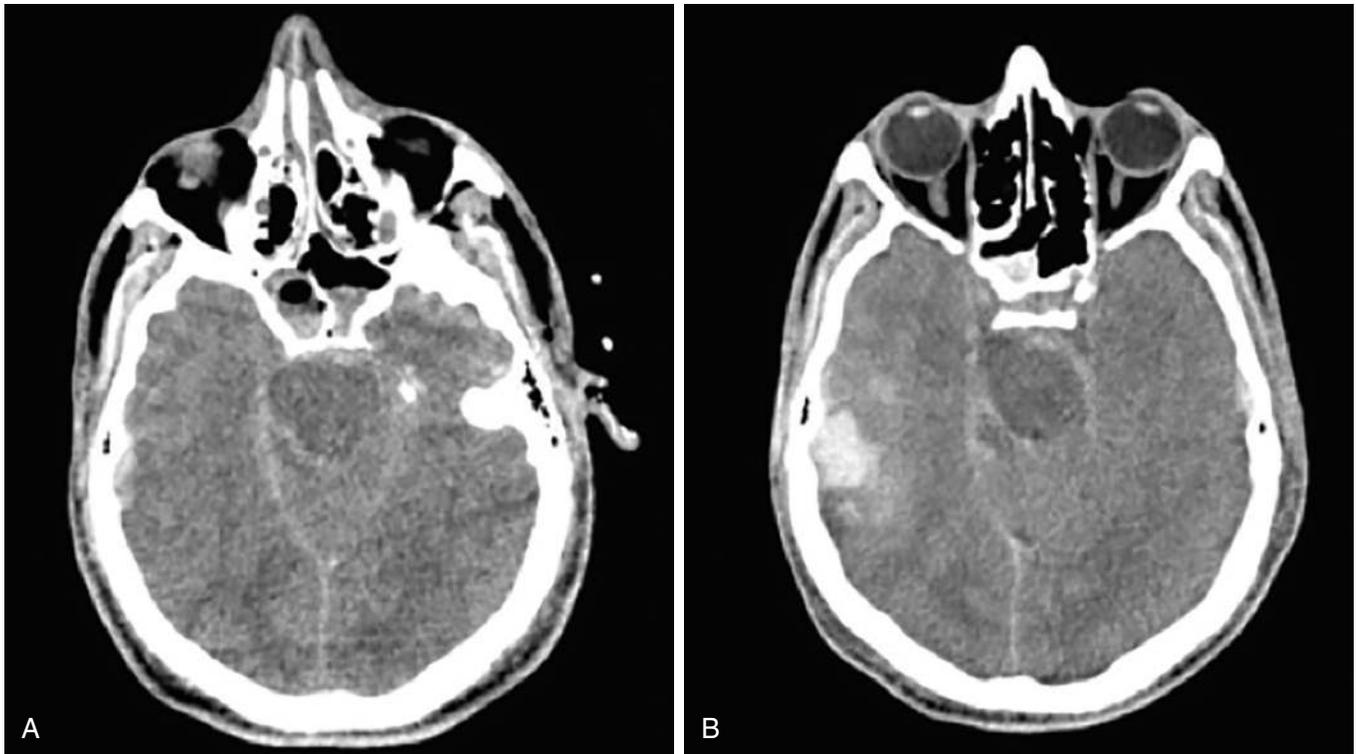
Cerebral contusion. A, Noncontrast CT shows a subtle area of cortical hypodensity and interspersed hyperdensity along the inferolateral right temporal lobe in this patient with closed head injury representing a cerebral contusion. B, CT performed 24 hours later shows marked progression of the hemorrhagic right temporal lobe contusion.
